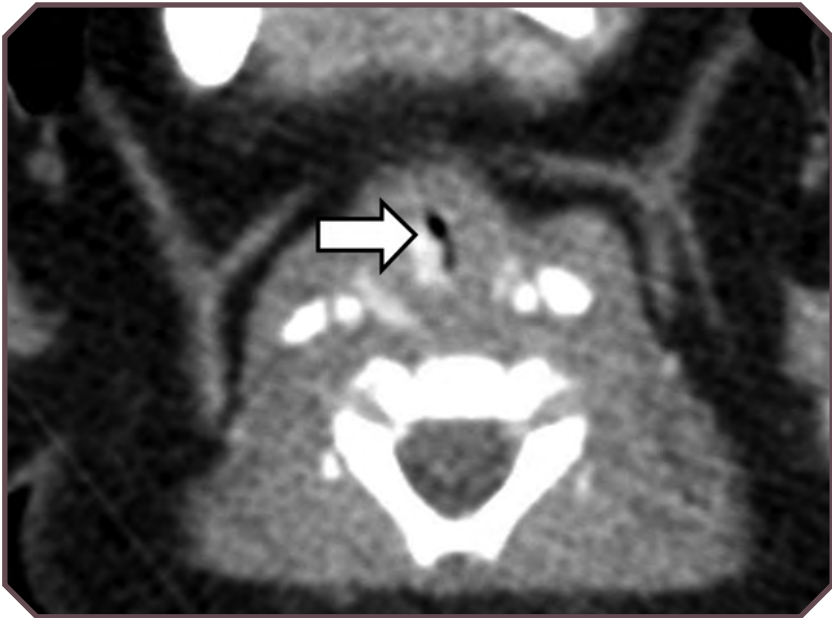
Infantile hemangioma in a 3-month-old male infant. Axial computed tomographic image demonstrates a mass with contrast material uptake along the right side of the airway (arrow) in this infant with multiple infantile hemangiomas.
